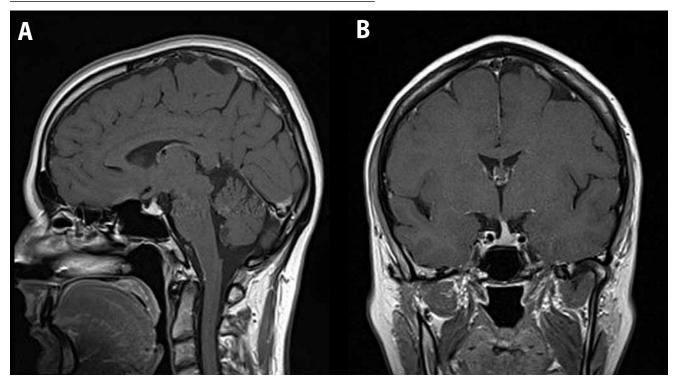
Postoperative sagittal (A) and (B) view T1 weighted gadolinium-enhanced MRI scan (17 months after surgery) shows only a small remnant of the cyst abscess.
